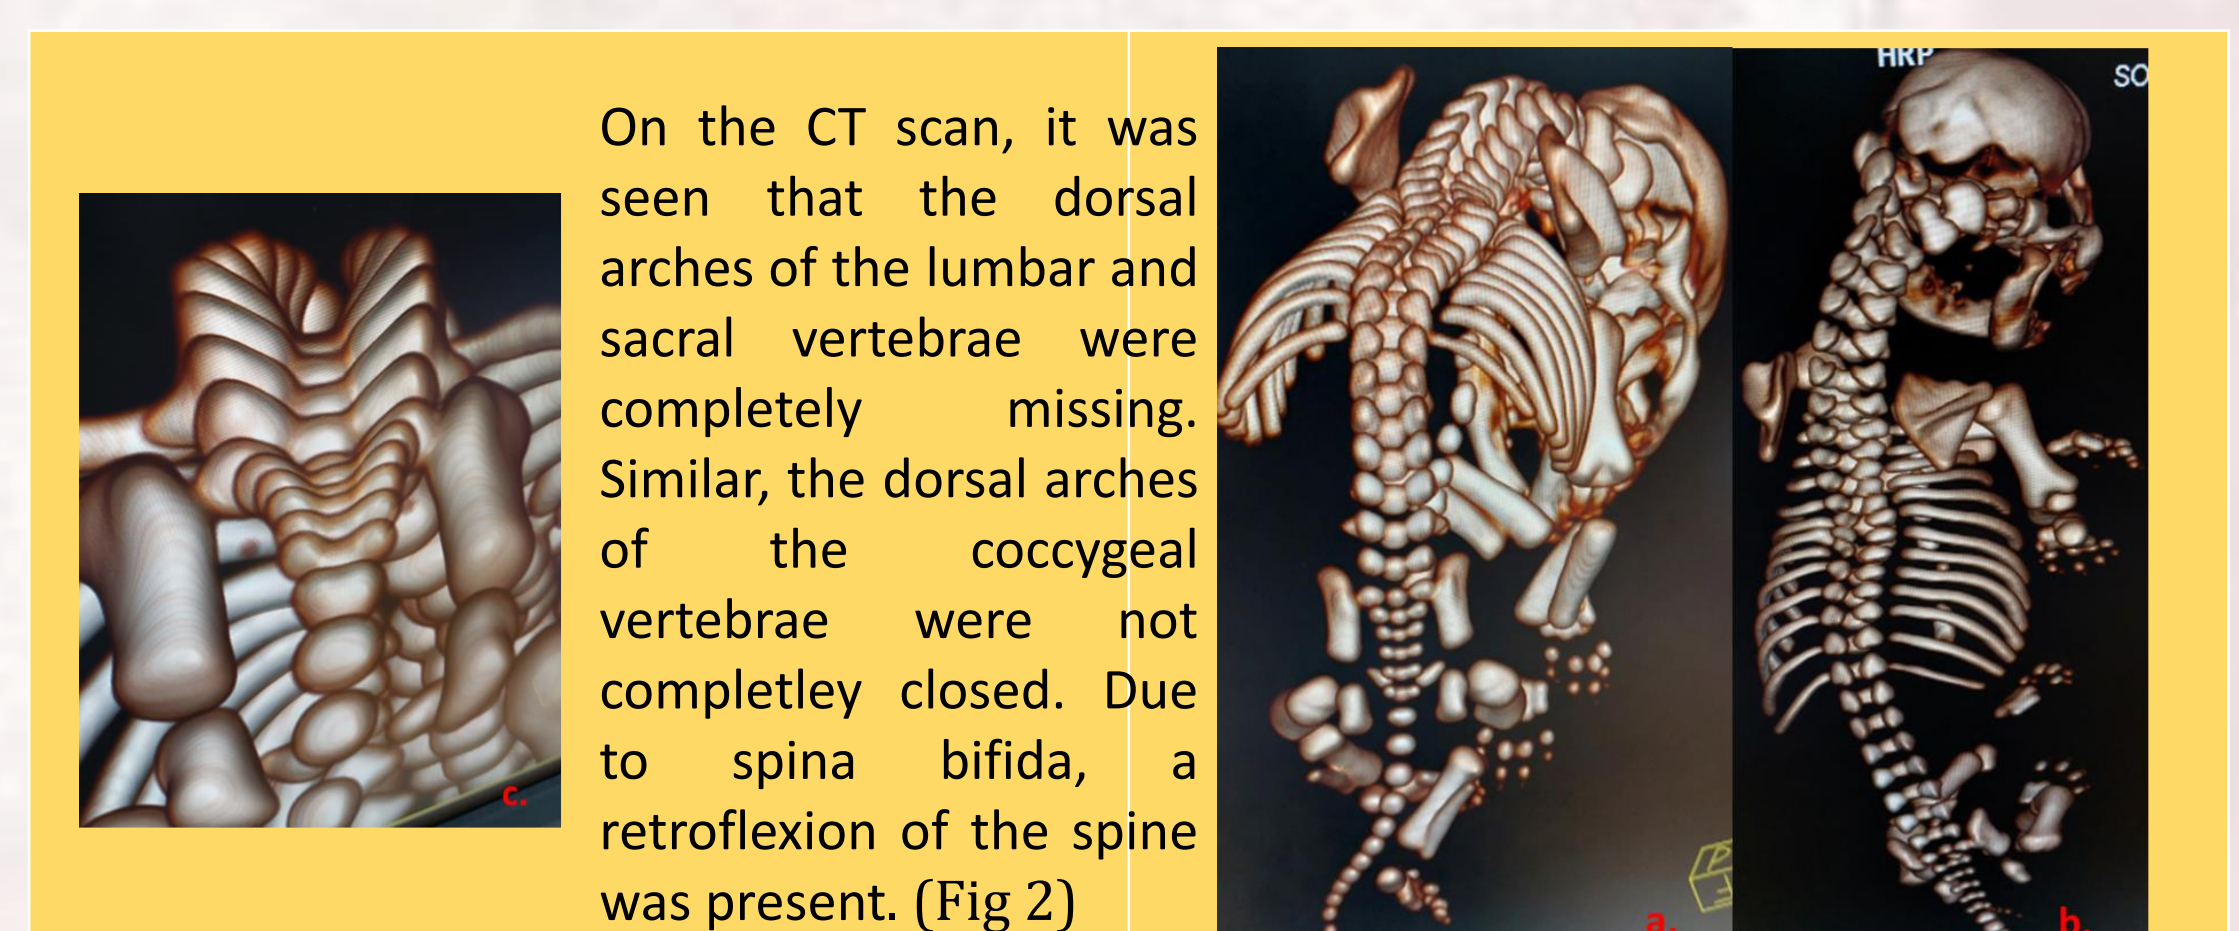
CT images (a&b The whole spinal cord aspect, thoracal retroflexion is observed, c. Focused image on lumbo-sacro-coccygeal vertebrae)
